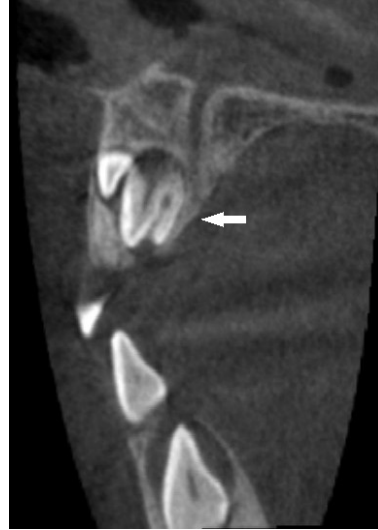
Sagittal cone-beam computed tomography (CBCT) scan revealing that one of the supernumerary teeth is associated with dens in dente tooth malformation (indicated by arrow).
